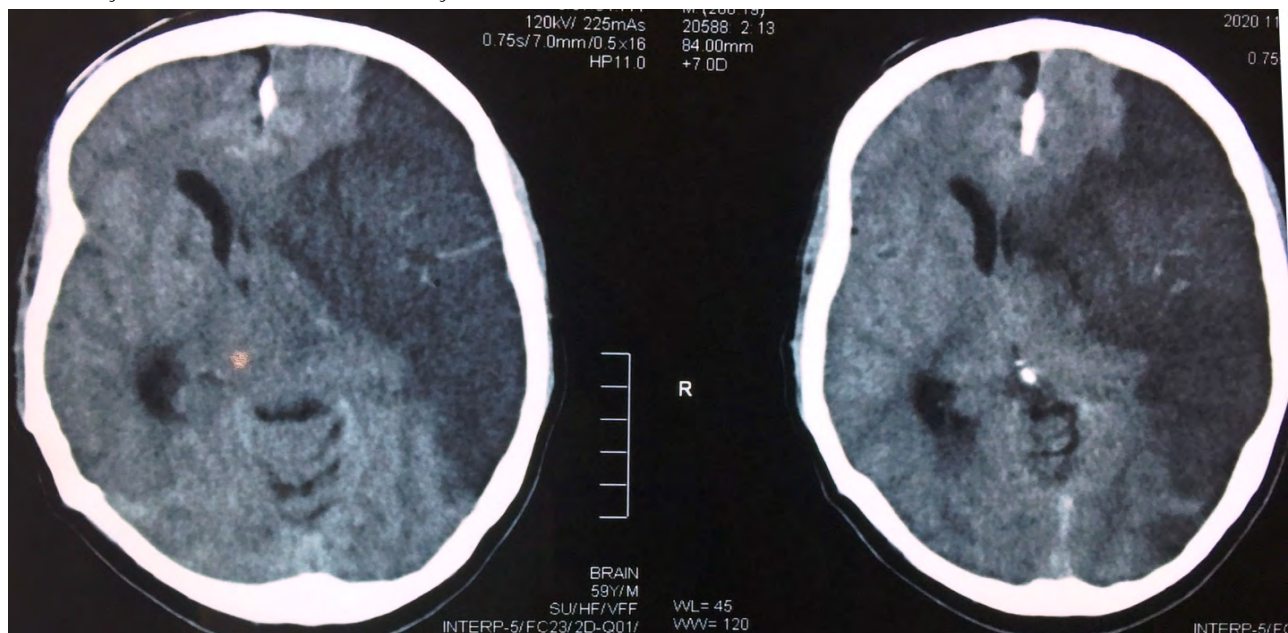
CT-Scan brain showing massive left frontal, parietal and occipital infarct.
